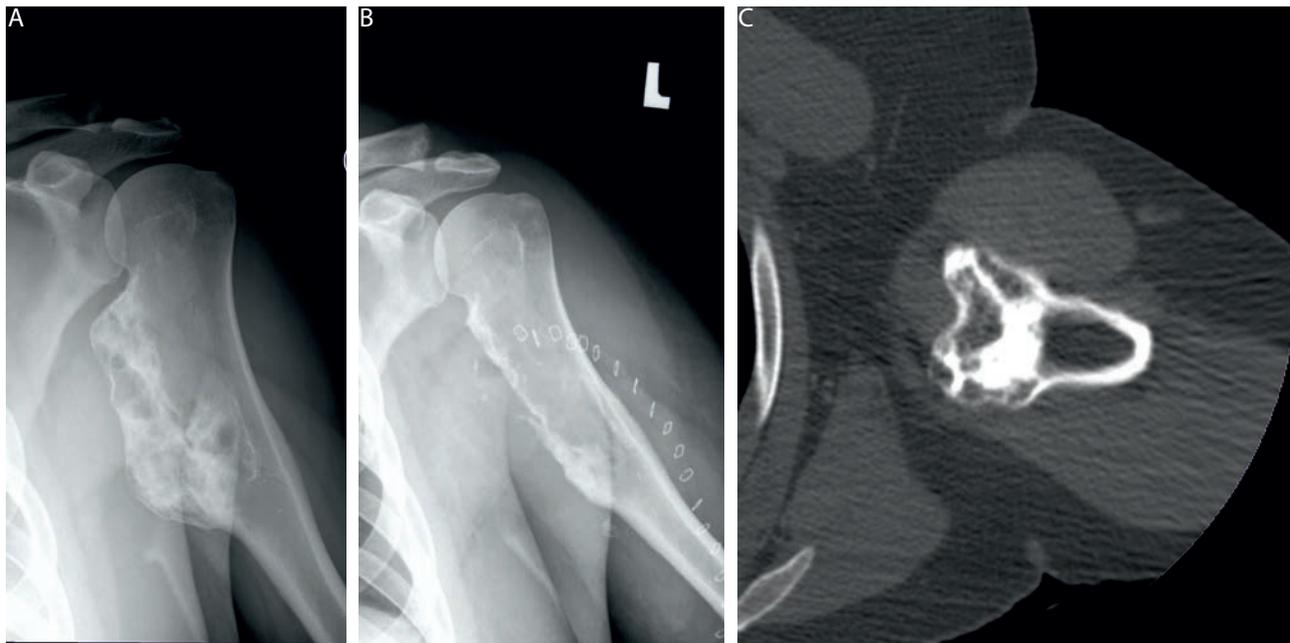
A-B – Patient, aged 37, a broad basal osteochondroma of the arm. C – CT reveals a depression in the superficial layer of the osteochondroma in which the vessels and nerves lay.
